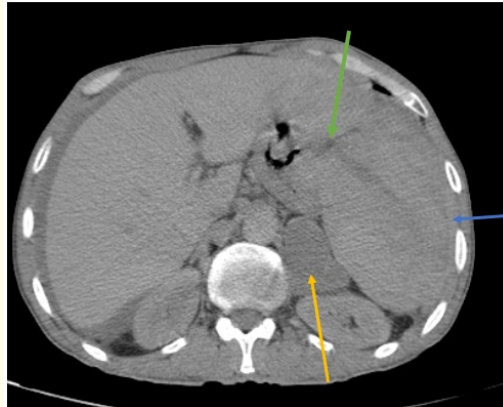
Axial section of an abdominal CT scan following contrast injection demonstrating: a heterogeneous spleen with splenic lacerations (green arrow), a subcapsular splenic hematoma (blue arrow) and perihepatic fluid accumulation. Note: Left retroperitoneal adenopathy with necrotic center (yellow arrow).
